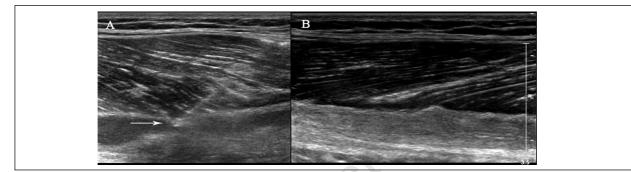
A 26-year old man with a grade II muscle injury. (A) Ultrasound image showing the position of the needle (arrow) and a haematoma that has infiltrated the muscle. (B) Ultrasound image showing hyperechoic scar tissue in the site of the injury 2 weeks after the end of the treatment.
